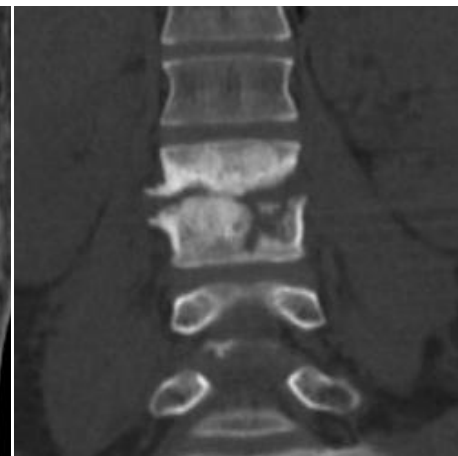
Lumbar CT scan, spondylodiscite L4-L5 (bone window)
